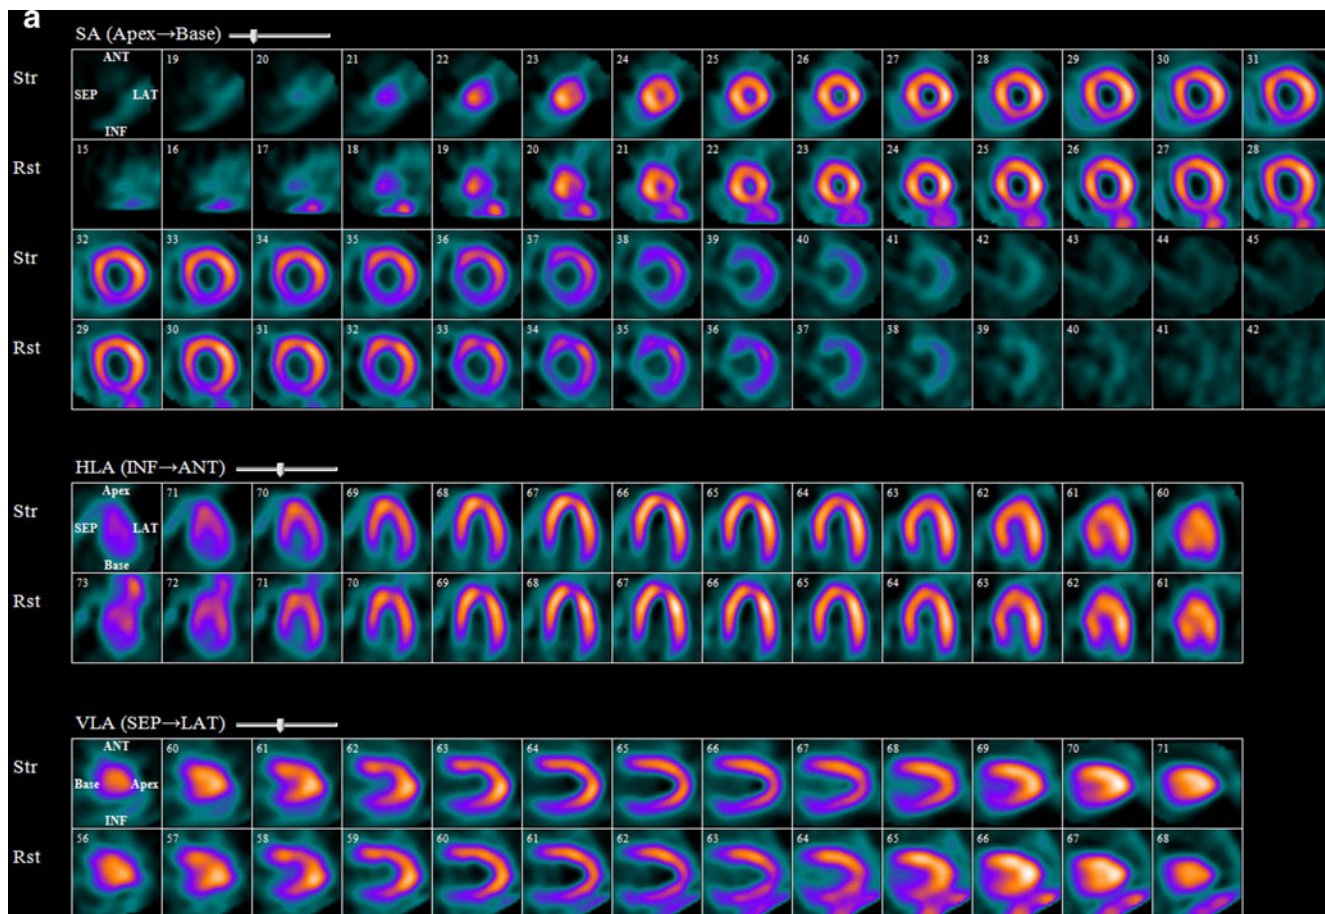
Static images of SPECT myocardial perfusion scintigraphy without (a) and with (b) CT attenuation correction. The apparent fixed defect in the inferior wall was corrected by CT attenuation correction using a hybrid SPECT/CT scanner confirming diaphragmatic attenuation
